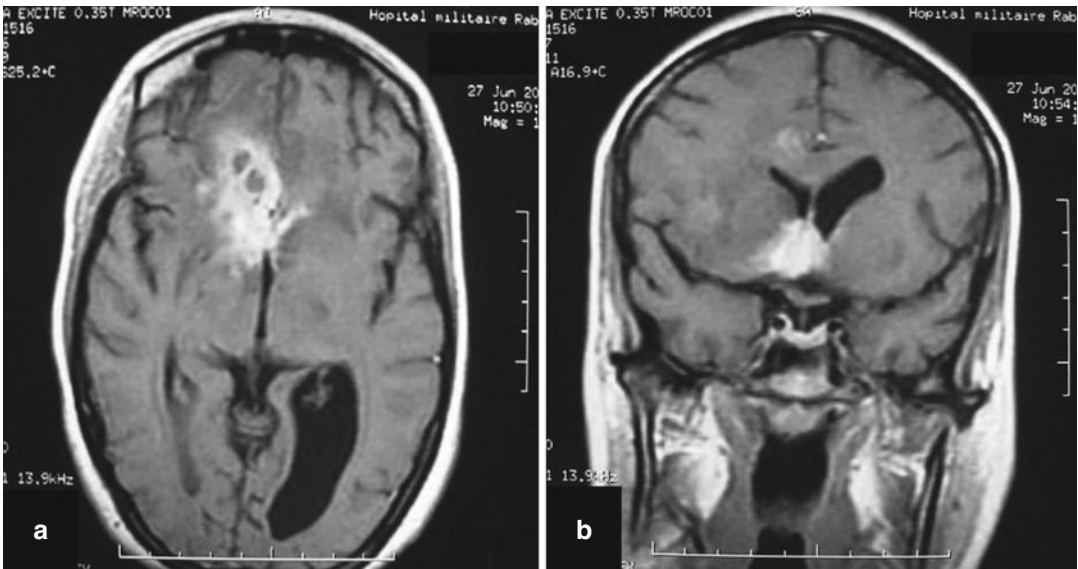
Axial (a) and sagittal coronal (b) T1-weighted MRIs with gadolinium infusion demonstrate a suprasellar-hypothalamic lymphoma with bifrontal extension
